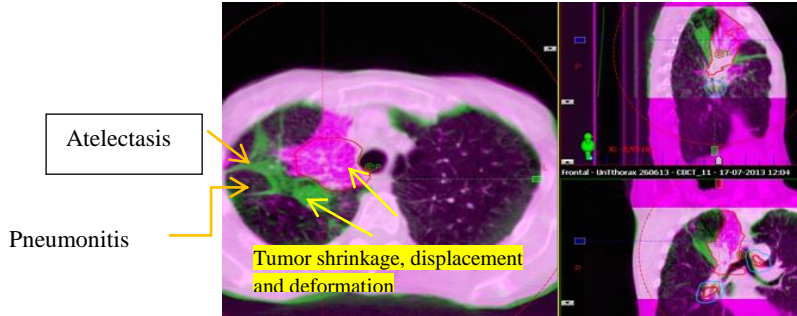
The bone registration of the CBCT at fraction 11 on the initial CT for patient 2 revealed a large anatomical change caused by atelectasis , pneumonitis and tumor shrinkage, displacement and deformation as a result of loosening from the thoracic wall
